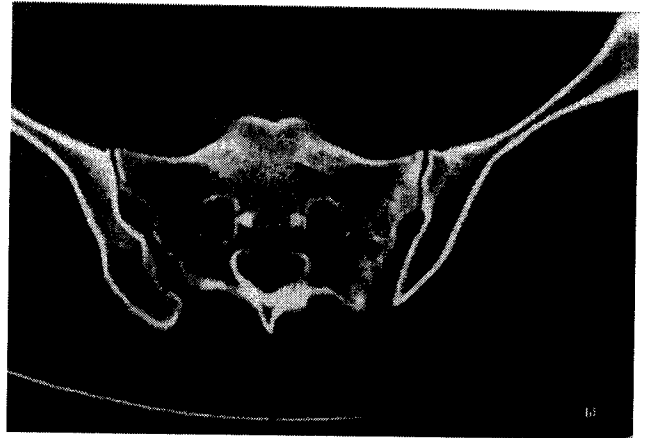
A coronal CT scan of the pelvis in case 3, performed 4 months after injury, demonstrates patchy sclerosis in the left sacrum parallel to the sacroiliac joint (arrows).
